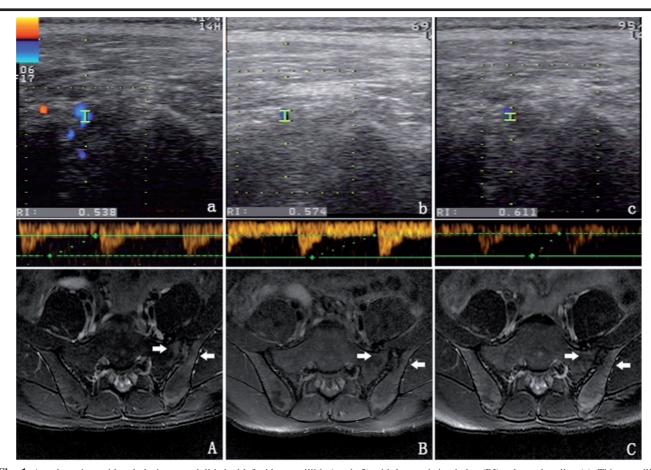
A male patient with ankylosing spondylitis had left side sacroiliitis (grade 3) with low resistive index (RI) value at baseline (a). This sacroiliitis can also be seen on MRI (A, arrows); The Doppler signal reduced significantly (grade 1) after 12 weeks of adalimumab and the RI value increased (b). The MR images also showed decreased inflammation (B, arrows); The RI value continued to increase after 24 weeks of adalimumab (c) and the blood signal remained little (grade 1). The inflammation seen by MRI was further decreased (C, arrows).
